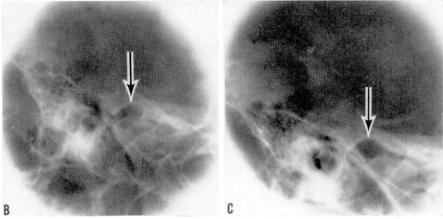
A, Photograph of upper complete denture and appliance. Note screws that temporarily adjust occlusion against the lower denture. B, Roentgenogram of right temporomandibular joint. Jaws are closed without the denture. Arrow points to top of fossa. C, Roentgenogram of right temporomandibular joint. Jaws are closed. Dentures are in place. Note effective distraction of the joint by the denture appliance. Arrow points to top of fossa. (The prosthesis was constructed by T. S. Malson, D.D.S., Cleveland, Ohio.)
